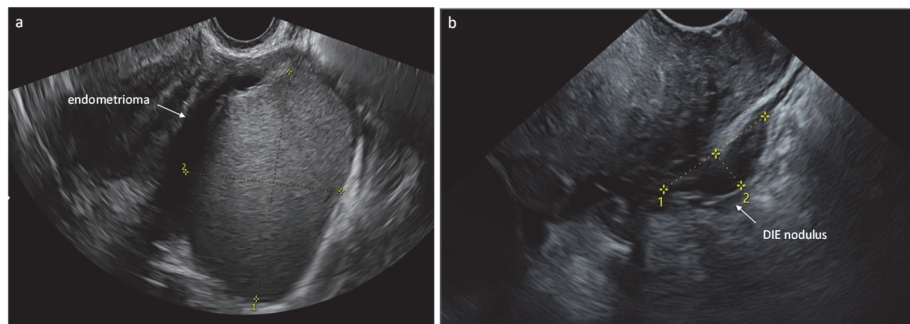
Transvaginal ultrasound image of a) ovarian endometrioma (OMA) and b) deep-infiltrating endometriosis (DIE) nodule. Permission from the patient to publish.
